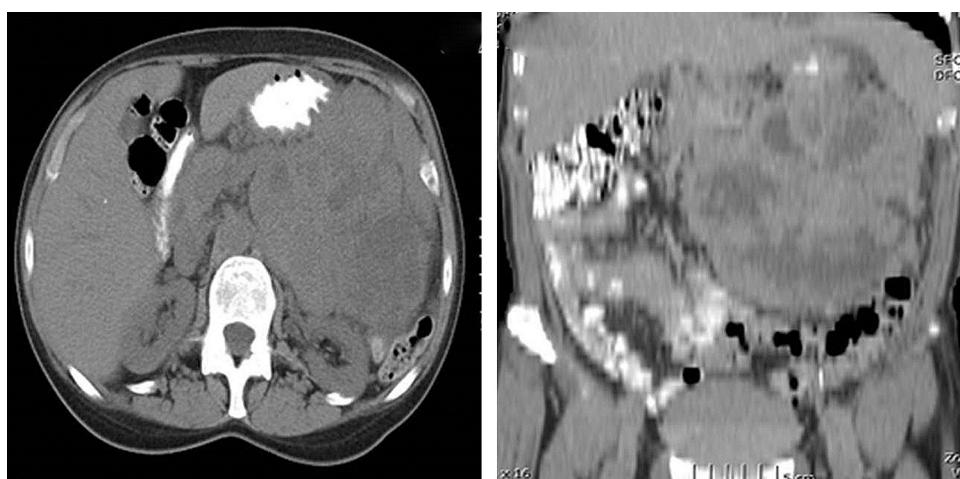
CT scan of abdomen and pelvis showing soft tissue mass with multiple fluid areas and areas of necrosis, with poor definition of the tail of the pancreas. It extends from the tail of pancreas to mid spleen and to the level of left iliac crest.
